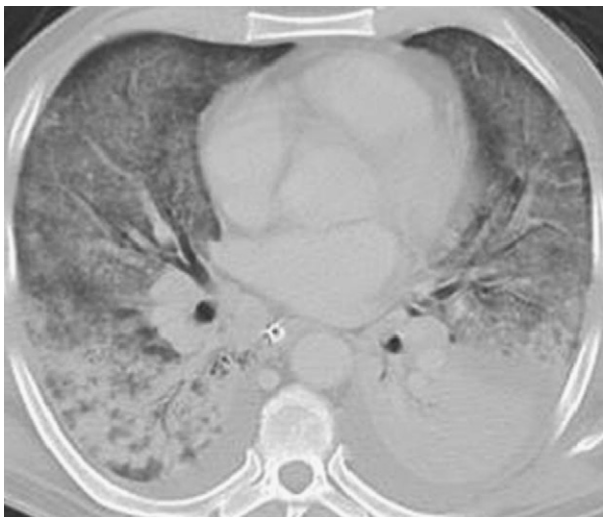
CT scan after drotrecogin alpha therapy. Despite rapid improvement in compliance and gas exchange, infiltrates persist and BAL is performed.
